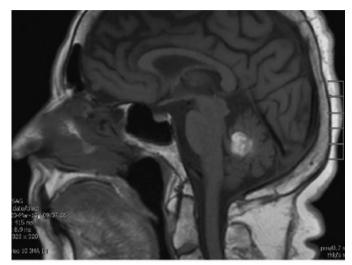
March 13th, 2023, a repeat MRI was performed revealing an increase in hematoma size measuring approximately 2.2 x 1.7 cm, previously 2.0 x 1.7 cm.
